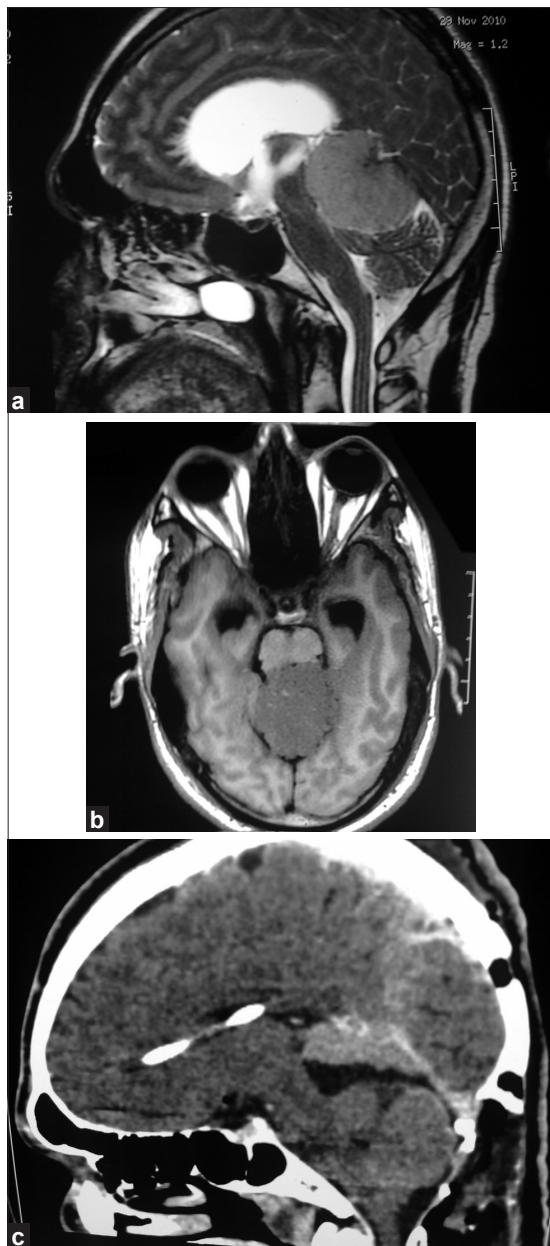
Tentorial meningioma with post op CT scan s/o residual adherent to deep veins
